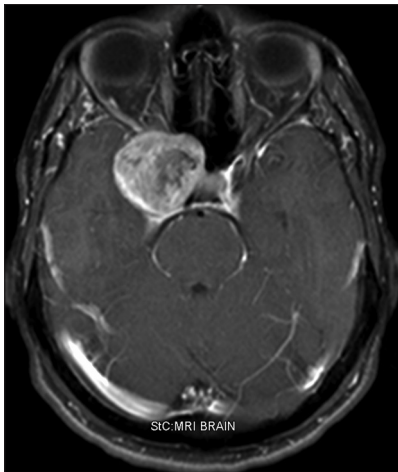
Axial magnetic resonance imaging brain with contrast before the first surgery, showing extra-axial heterogenous mass (meningioma) is seen in the right para-sellar region
